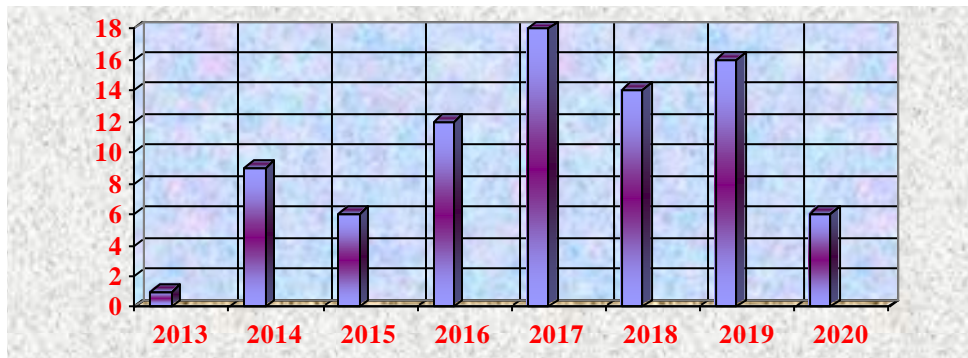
Doppler annual dynamics in all the patients with carotid stenting and angioplastics
